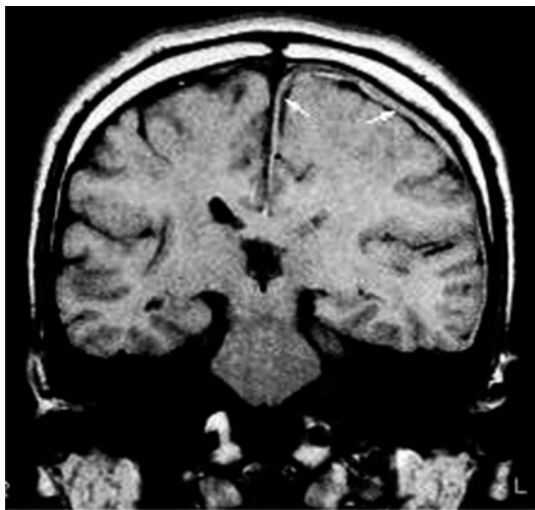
MRI coronal section showing a subdural hematoma over the cerebral convexity and interhemispheric (arrows)
